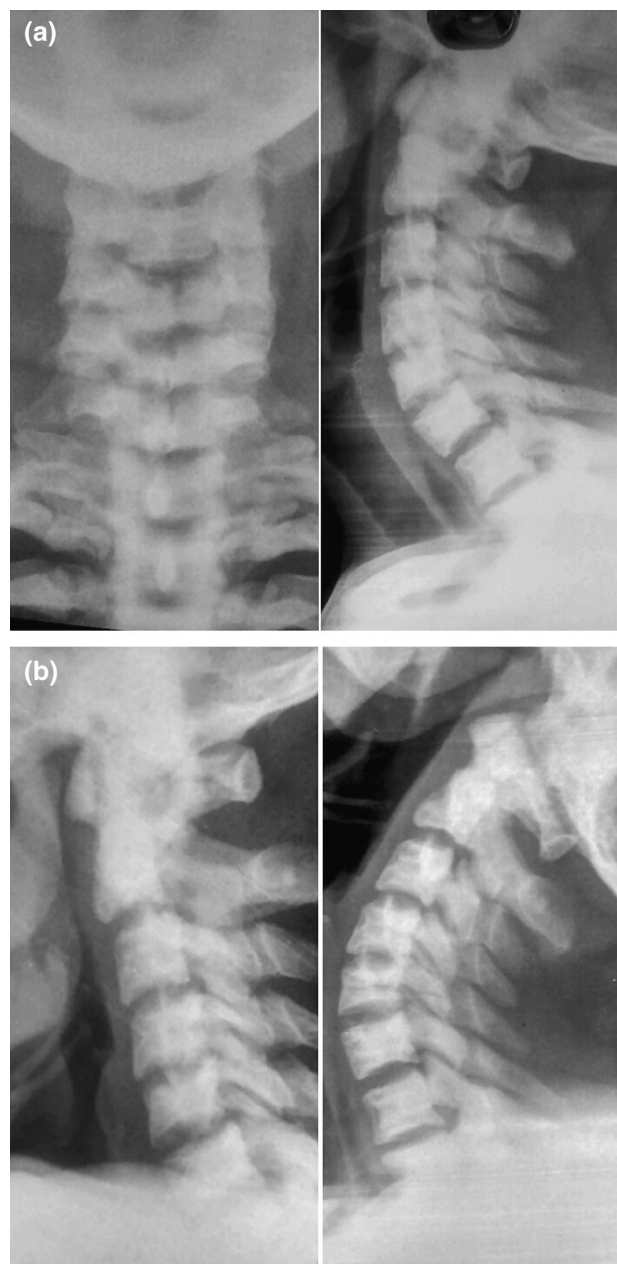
Follow-up X-rays at 2.5 years after injury a antero-posterior and lateral, b flexion and extension views
